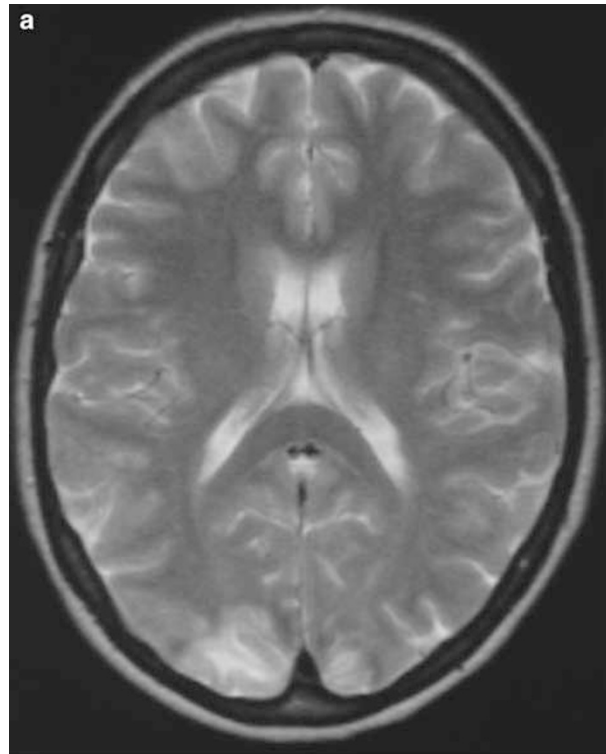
T2-weighted MRI of the brain. (a) At 1 week after the accident, MRI shows bilateral occipital cortical high signal intensity lesions more marked on the right side, consistent with nonhaemorrhagic contusions. (b) At 1 year after the accident, MRI shows focal bilateral occipital cortical loss, more on the right side, consistent with gliosis or focal atrophy secondary to previous contusion.
